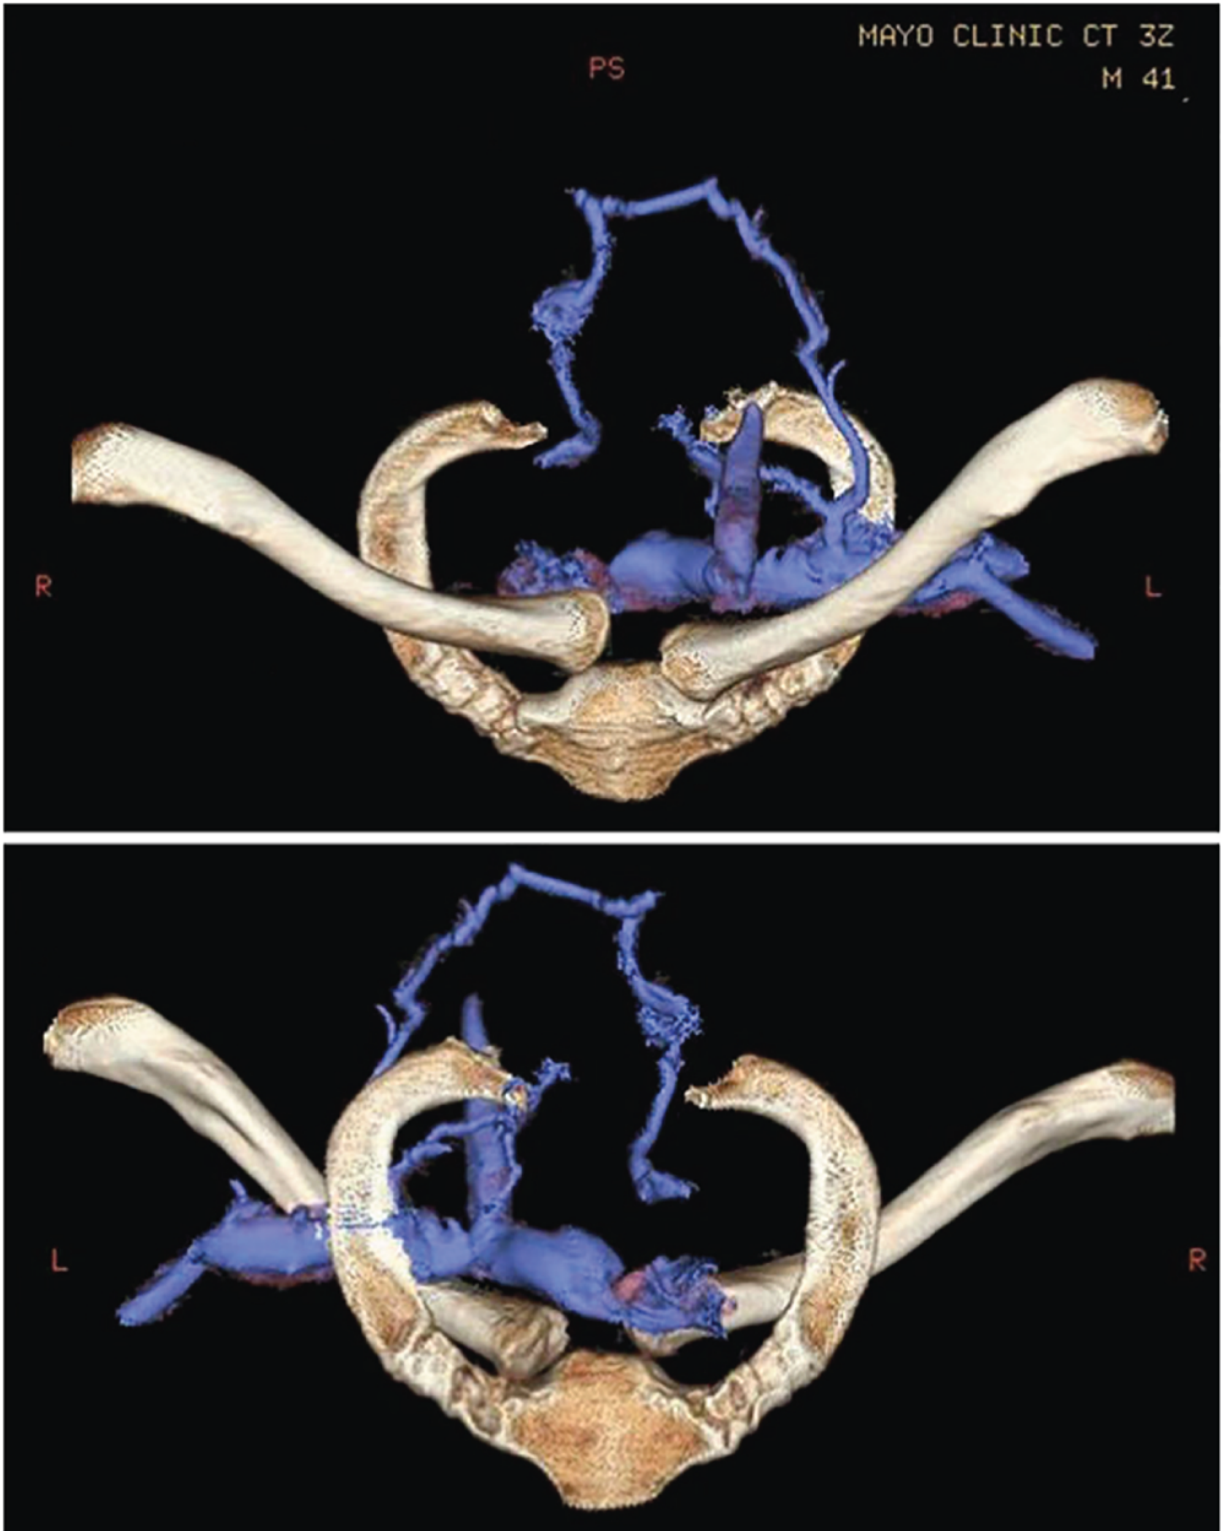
3D CT reconstruction of a right posteriorly dislocated SC joint with venous compression. Source: Imaged adapted from: Hoekzema.¹¹
